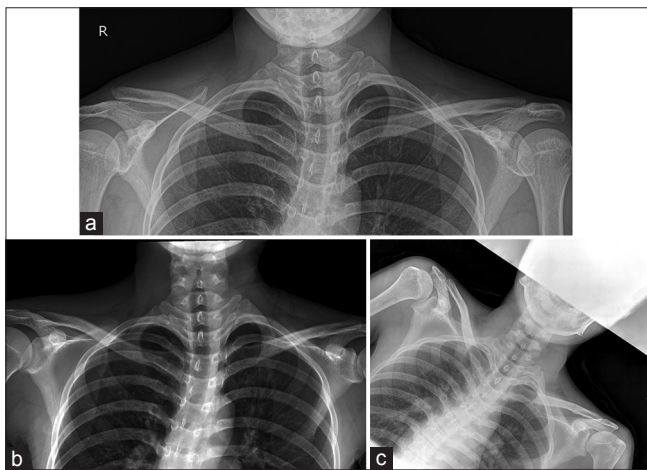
(a) Anteroposterior standing radiograph with the stress maneuver of 21-year-old male patient shows the right AC joint separation with Type V before the operation, (b) which is reduced by combined option B-1 and B-2 procedure, (c) and maintained well at final followup
